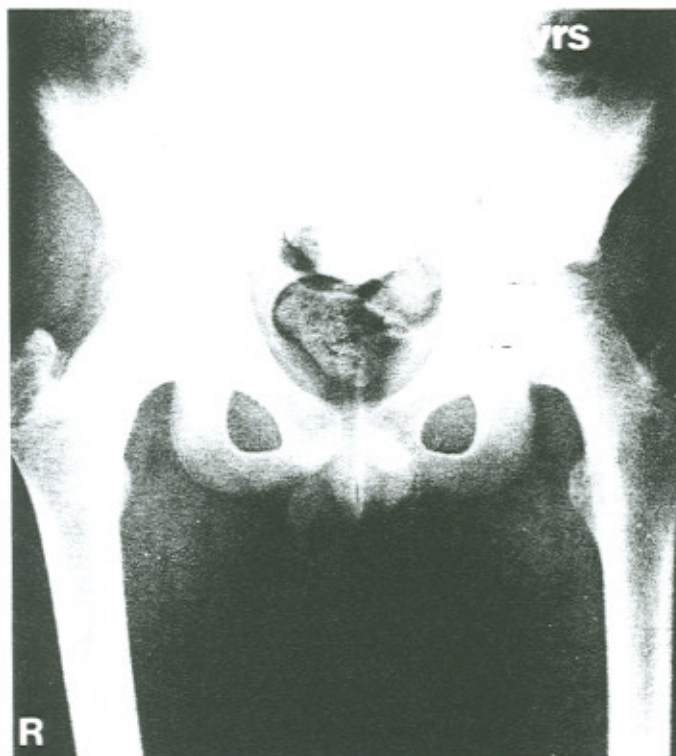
An anteroposterior pelvic radiograph of a 12-year-old male which was initially interpreted as normal. However, when both sides are compared, a partial slip of the left femoral epiphysis is evident. Also note the blurred and widened metaphyseal margin on that side.
